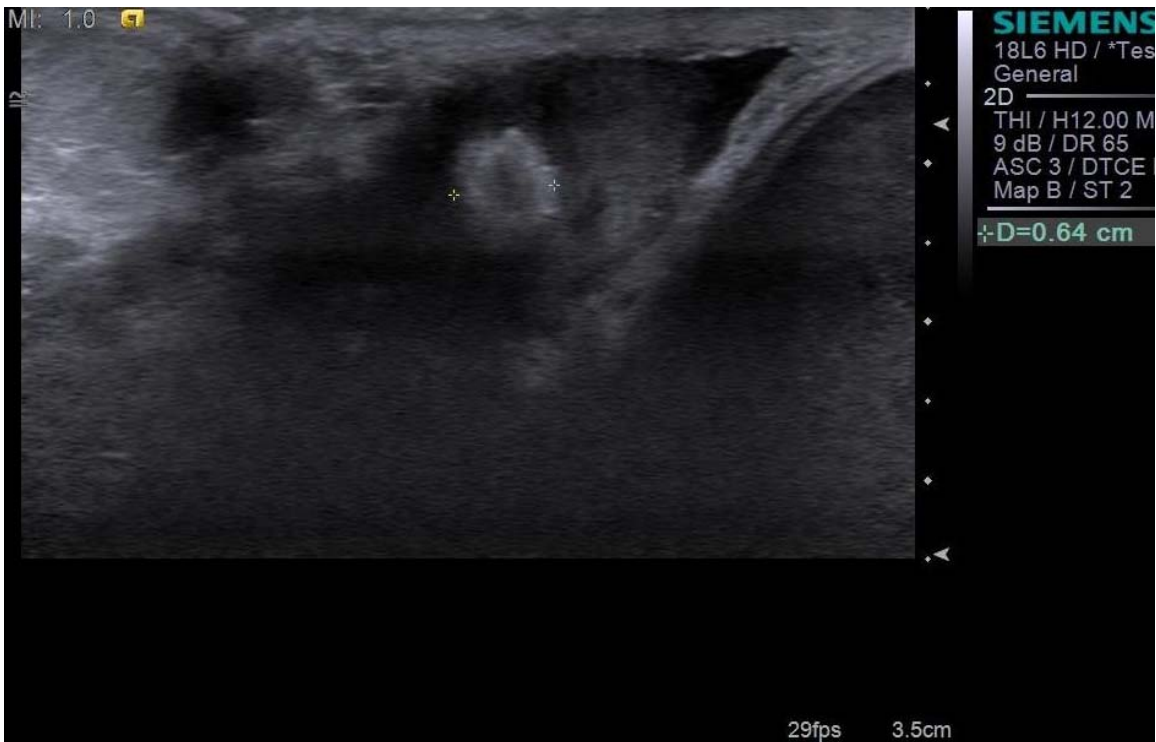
Transverse grayscale ultrasound image of the upper pole of the right testis again demonstrates the echogenic lesion.
